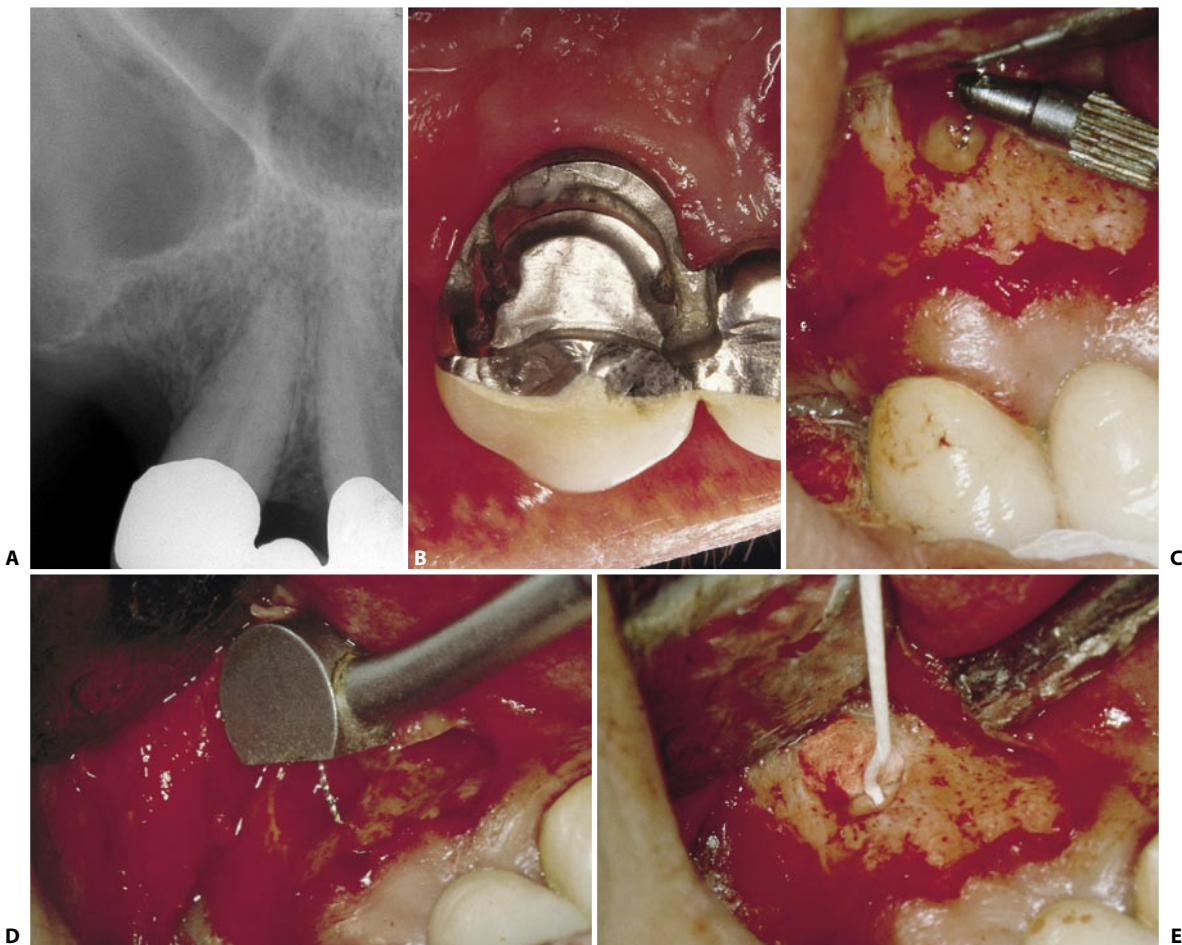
A. Preoperative radiograph of an upper right cuspid with pulpitis. The onset of acute symptoms was one week following definitive cementation of the prosthesis. B. Palatal view of the prosthetic crown of the cuspid, on which the removable prosthesis is attached. Unable to perform an adequate access cavity, since this would have entailed destruction of the intracoronal attachment and then the need to remake the prosthesis, a surgical approach was chosen. C. A flap has been raised, and the root has been bevelled. The root canal is now cleaned and shaped with hand files. D. Cleaning and shaping is completed with ultrasonic instruments. E. The canal is dried with sterile paper points (continued).
